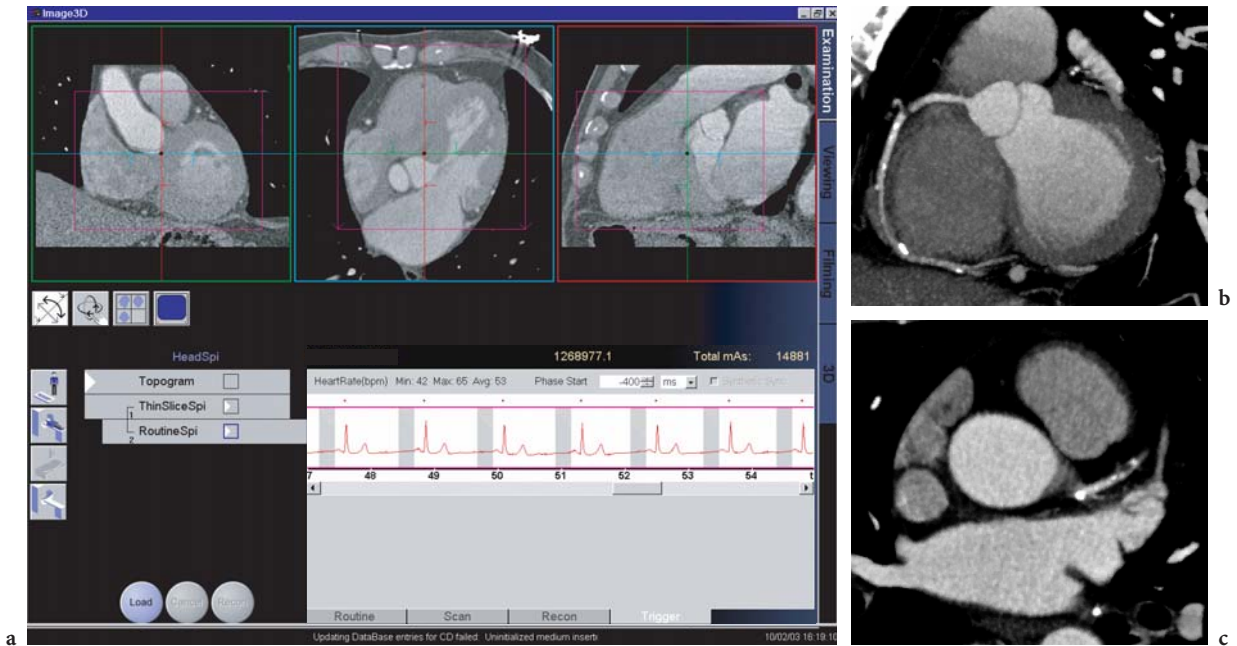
Direct MIP reconstruction for a cardiac CT examination obtained on a 16-slice CT scanner. True 3D-based planning of the MIP views (a) enables direct reconstruction of MIP stacks from the scan data with pre-defined MIP slab thickness and increment. The usual step of generating axial slices can be skipped. In the example, the MIP stacks are generated in diastolic phase using RAO (b) and LAO (c) projections. (Case courtesy of Tübingen University, Germany)
